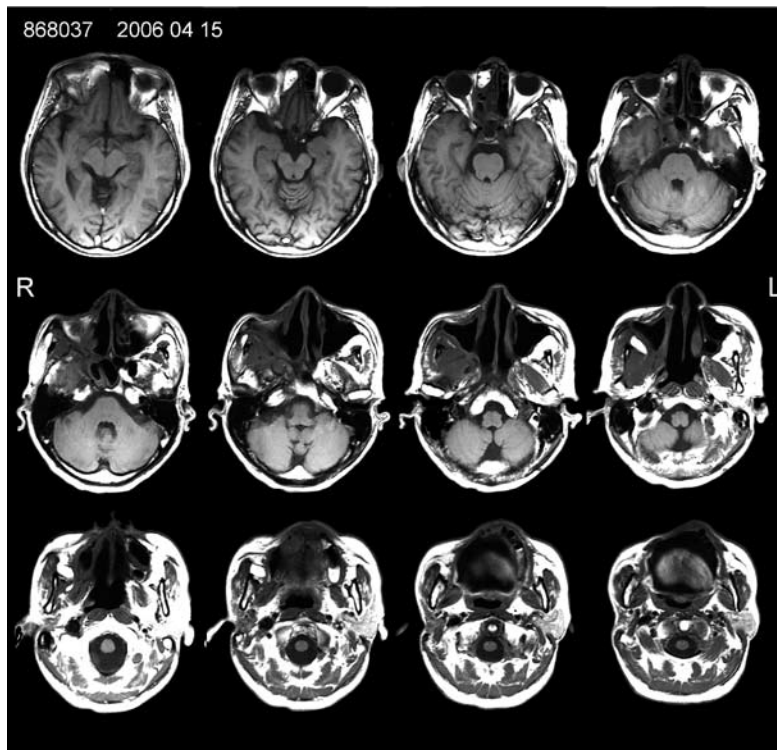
MRI of the patient 18 months after IMRT showing complete tumor regression
